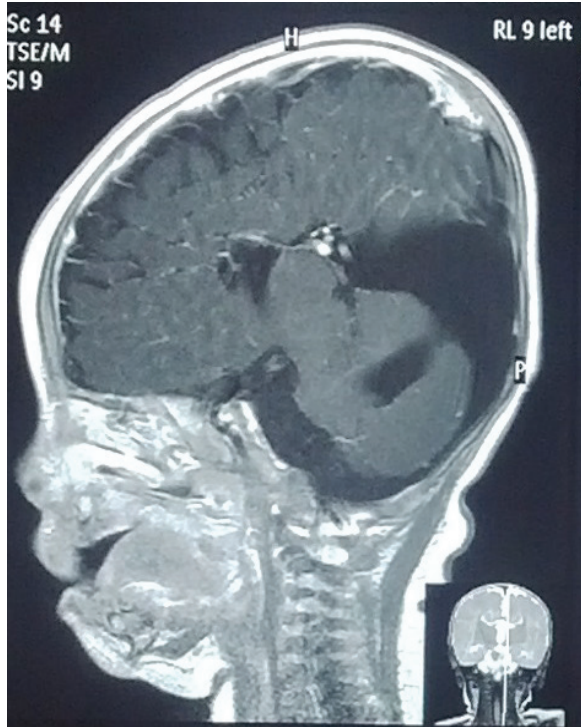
Head MRI showing for cranial posterior fossa cyst from sagittal view.
